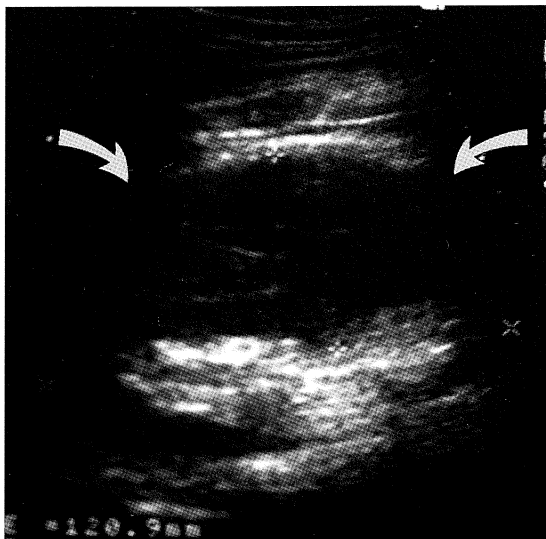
Post-ESWL ultrasound of the left kidney.
